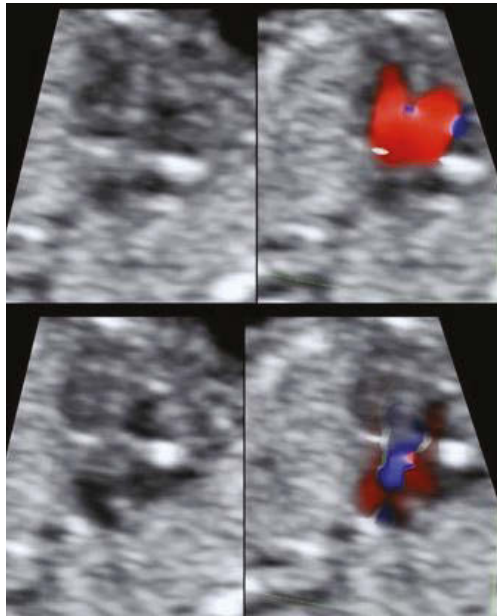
Atrioventricular septal defect (AVSD) seen in a B-mode with and without color Doppler mapping during diastole (upper) and systole (lower).
